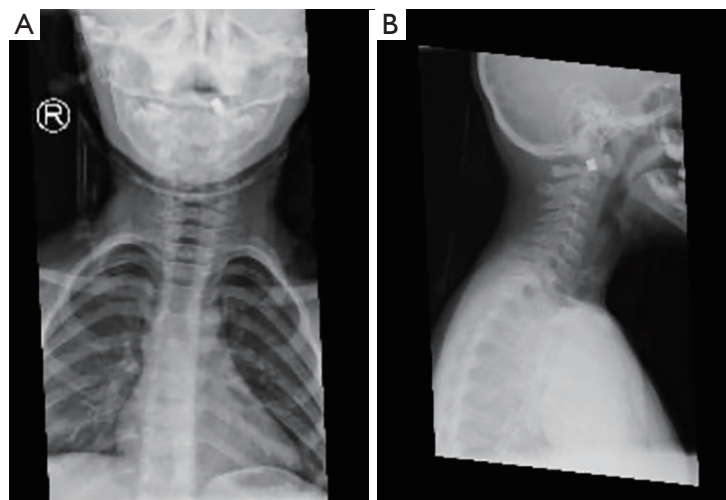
(A) Anterior-posterior view and (B) lateral view of cervical X-ray showing that the pellet is at the C1 level.
